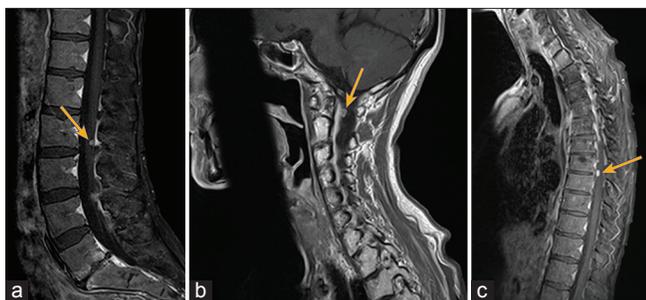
Sagittal T1-weighted magnetic resonance imaging showing contrast-enhancing dural-based lesions posterior to C2 vertebral body (a), posterior to T9–T10 disc space (b), and along the posterolateral dura at the L3–L4 level (c) (arrows)
